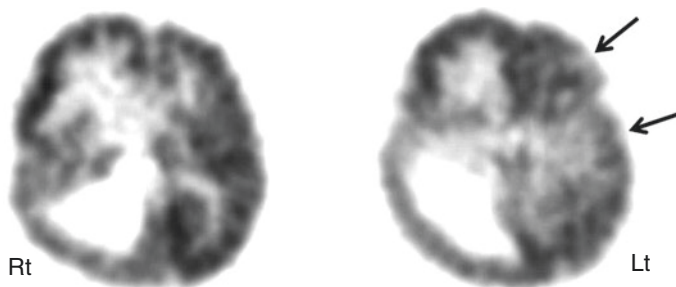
2-Deoxy-2(^{18}F)-fluoro-D-glucose PET scan in a child with right hemimegalencephaly showing an enlarged right hemisphere with increased glucose metabolism in the right frontal lobe because of epileptic activity during the radiotracer uptake period. Also noted are mildly hypometabolic areas in the frontal and temporal regions of the left hemisphere (*arrows*), indicating functional impairment of this hemisphere, which appeared to be normal on MRI. Although right hemispherectomy resulted in seizure freedom, the child remained developmentally delayed because of an abnormal left hemisphere
